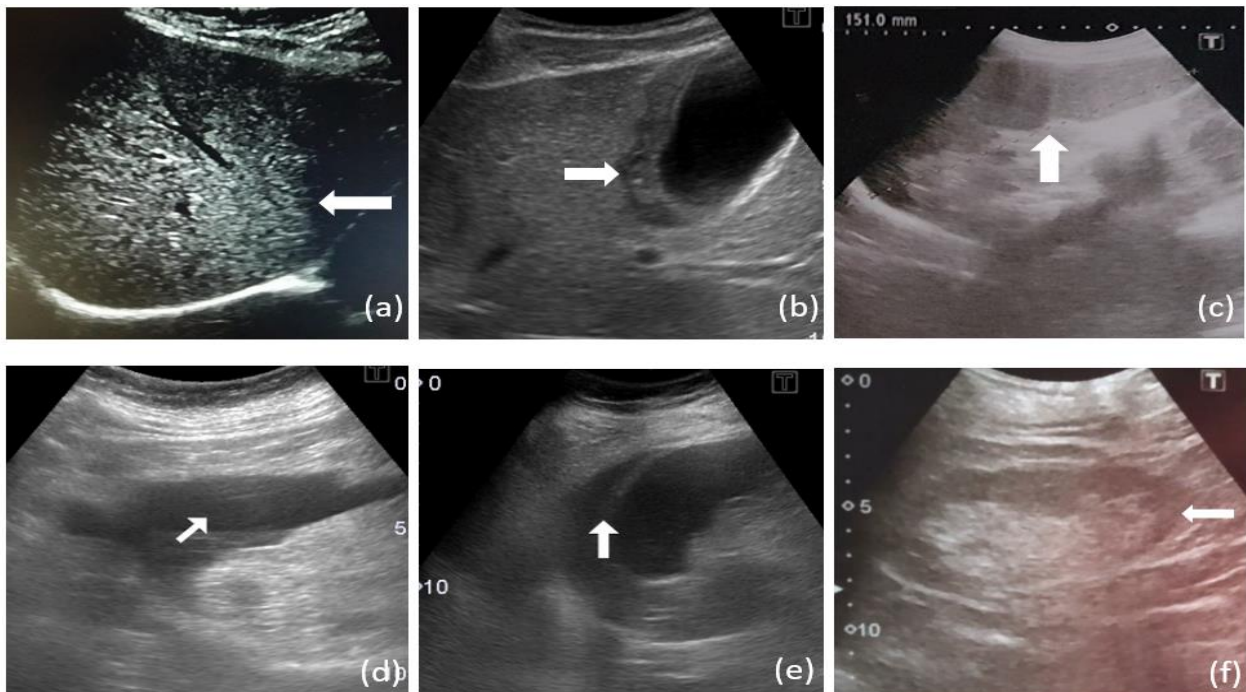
Ultrasound images of different patients showing hypoechoic liver (a), edematous gall bladder (b), splenomegaly (c), ascites (d), pleural effusion (e) and increased parenchymal echogenicity of left kidney (f).
